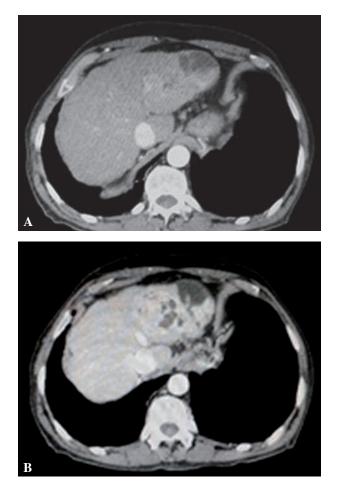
CT imaging of the second case. A. pre- images of TACE, B. an increase in the mass.
